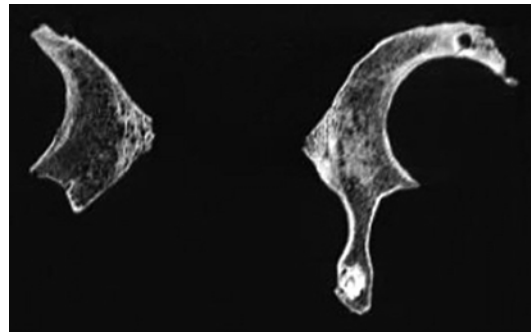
CT scan coronal plane multiplanar reconstruction shows a calcified lesion in the ischial tuberosity
